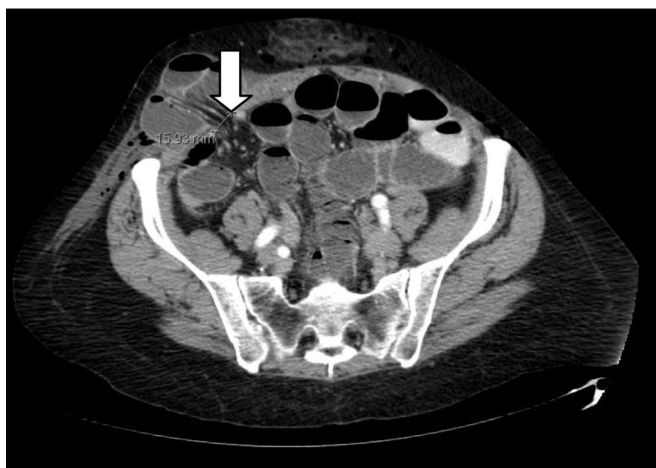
Computed tomographic scan demonstrating bowel herniation.
